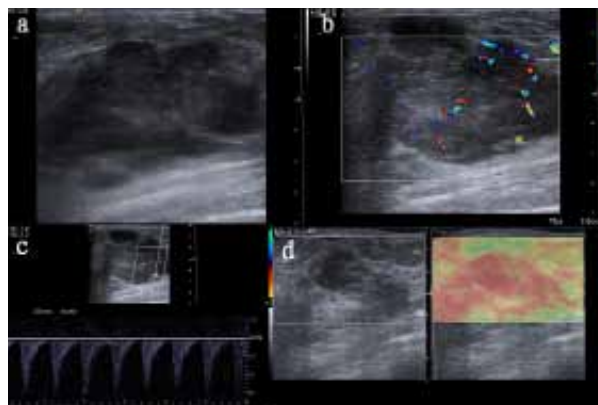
A 40 Year-old-woman with Lobulated Fibroadenoma. 2D ultrasound image showed a large lobulated hypoechoic mass (a), with heterogeneous internal echotexture. Intra-tumoral blood flow was profuse (b), RI=0.92(c). The UE score was 4 (d)
